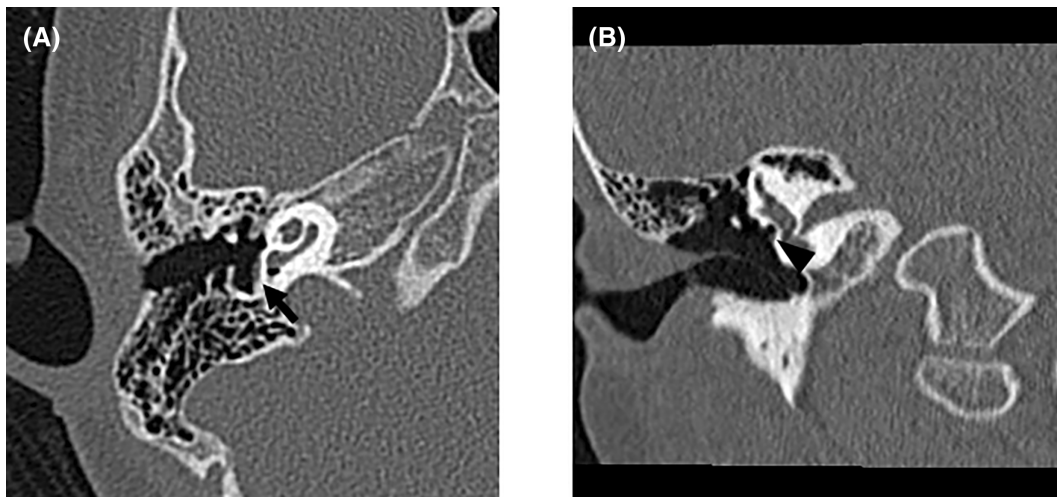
Computed tomography scan of the right ear. The facial nerve runs inferior to the oval window (A: Black arrow in axial view. B: Black arrowhead in coronal view).
